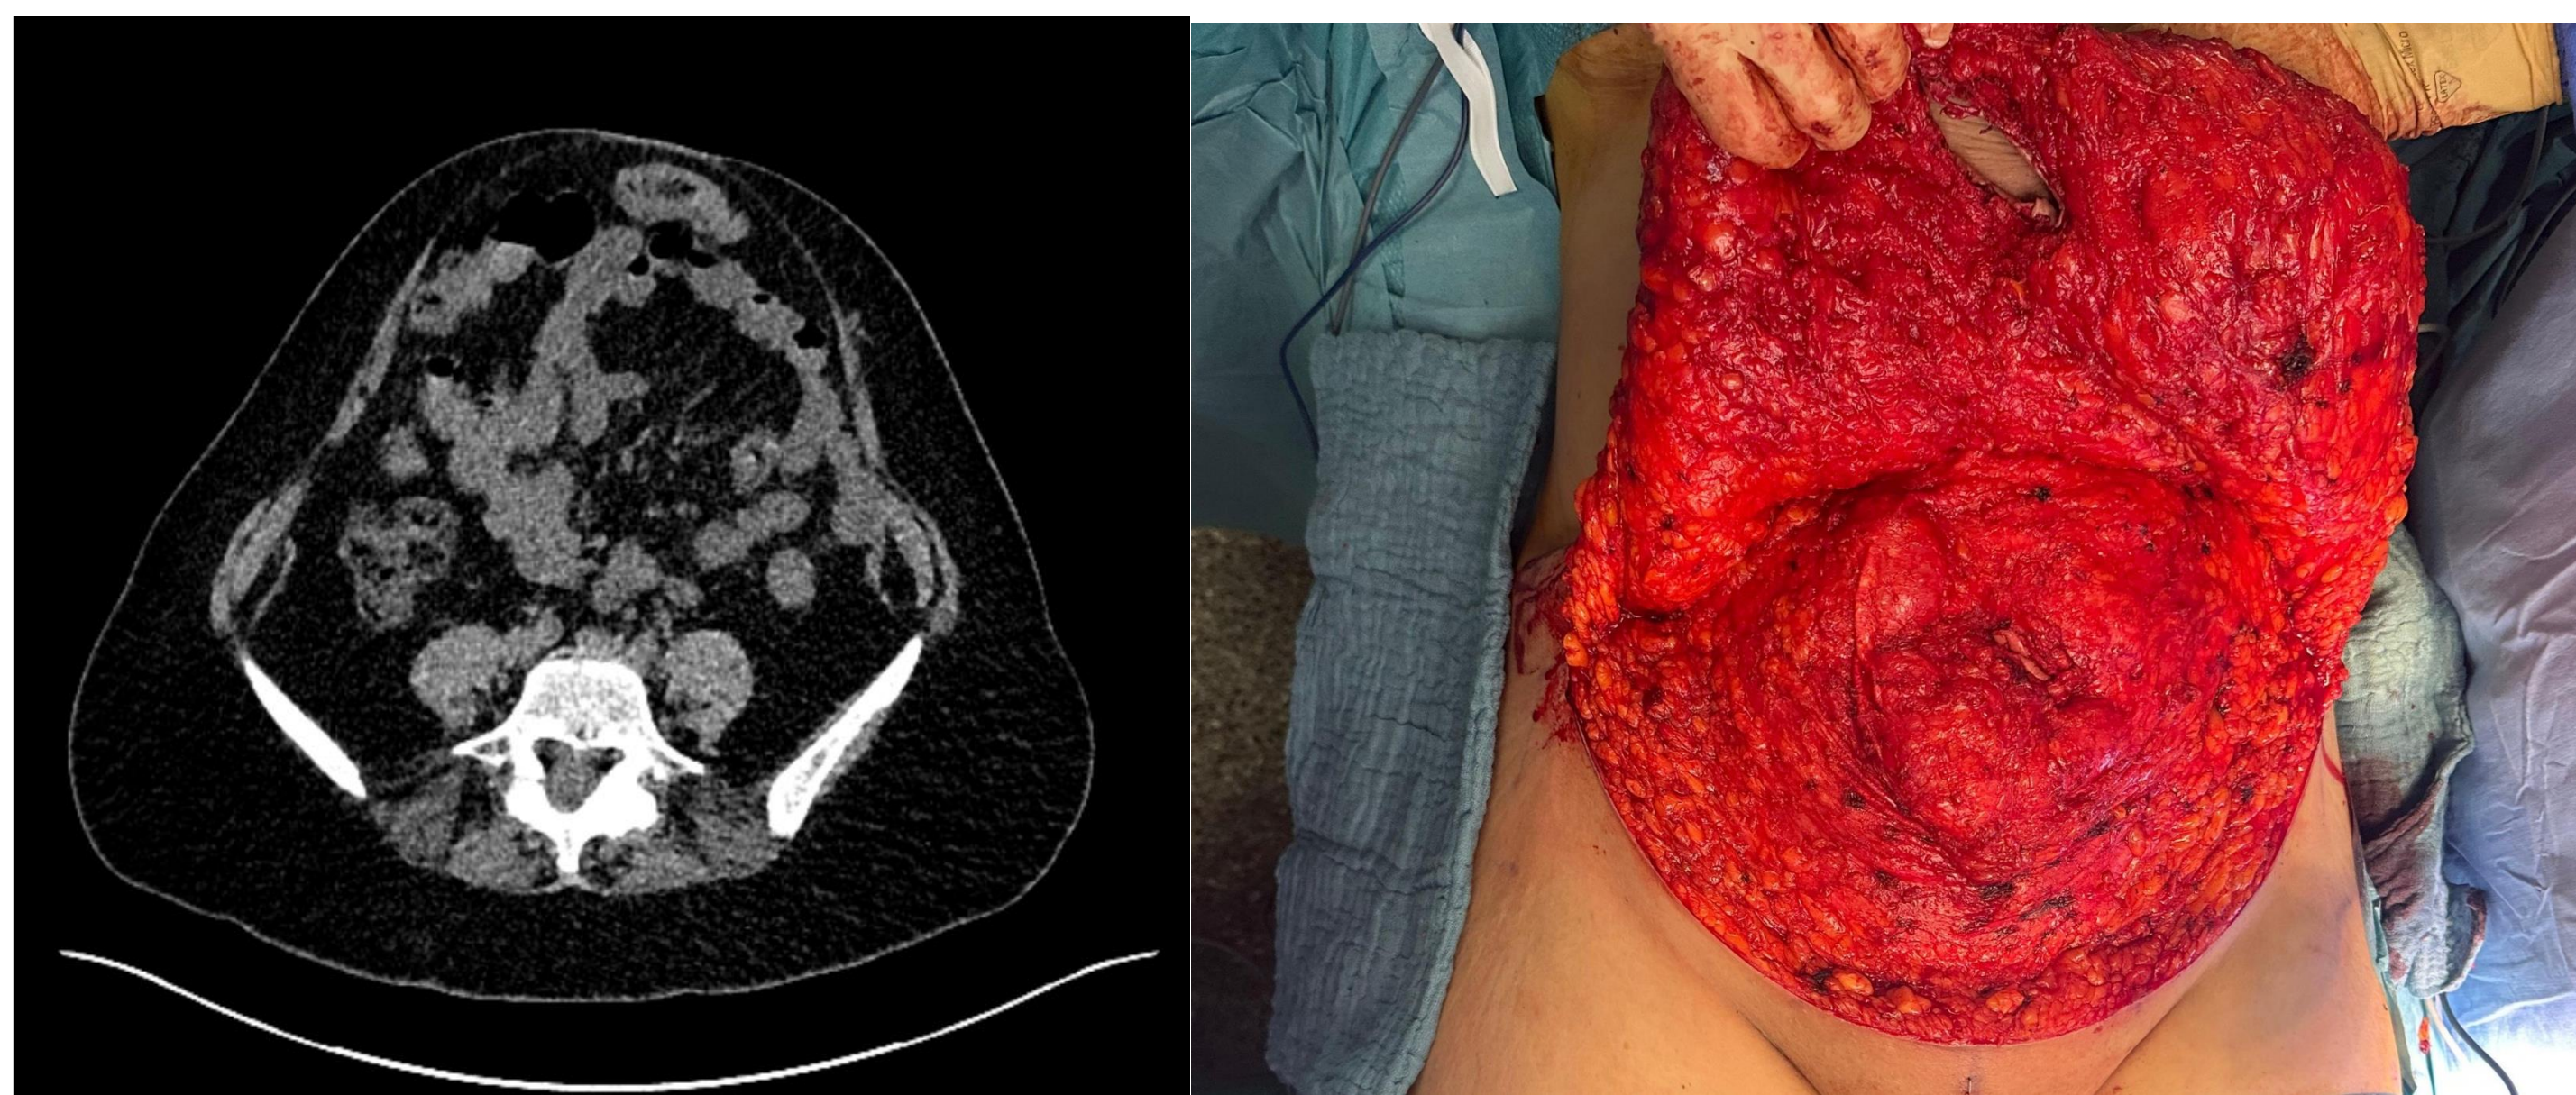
Preoperative abdominal CT-scan (left) and intra-operative view (right), showing the severe RD and associated umbilical hernia
